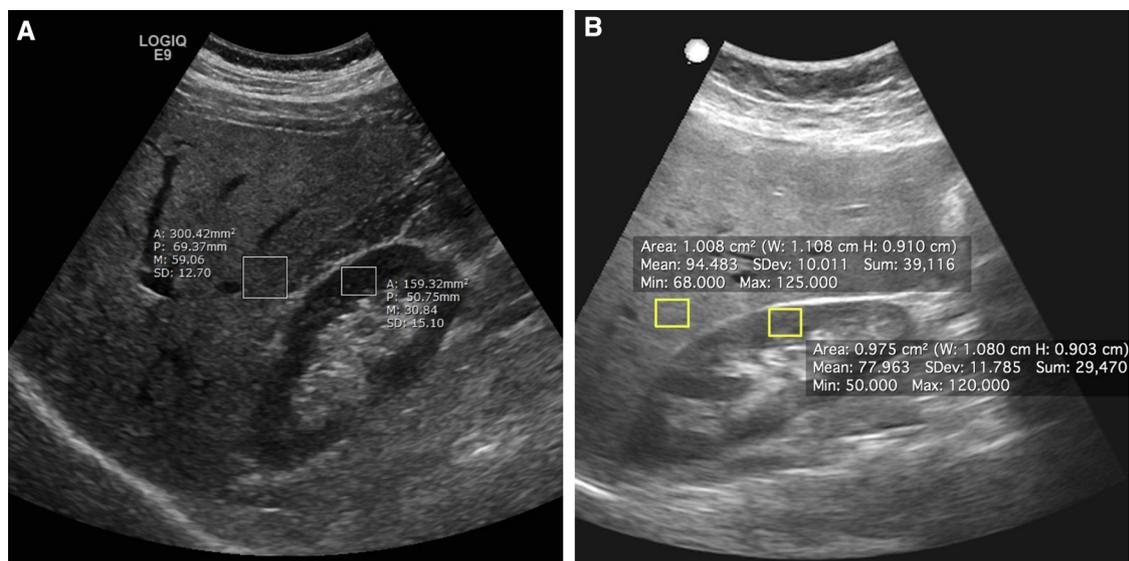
Regions of interest used to calculate the hepatorenal index for a 41-year-old female based on images obtained using the (A) LOGIQ E9 ultrasound system (conventional) and (B) SonixTablet/MELODY system (telerobotic).
